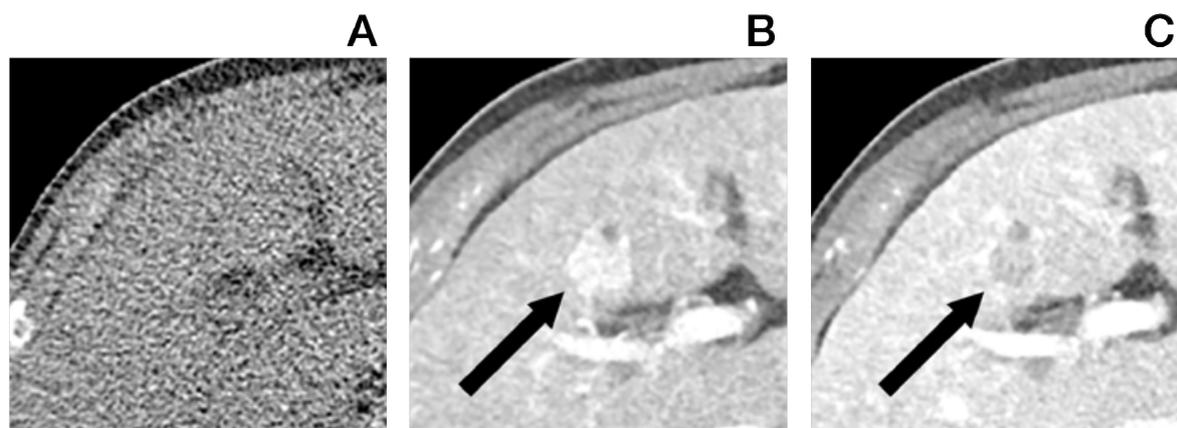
Computed tomography images of a hepatocellular cancer lesion in native (A), arterial (B) and portal-venous (C) contrast phase. Typical contrast uptake in the arterial phase followed by contrast washout in the lesion can be observed.
